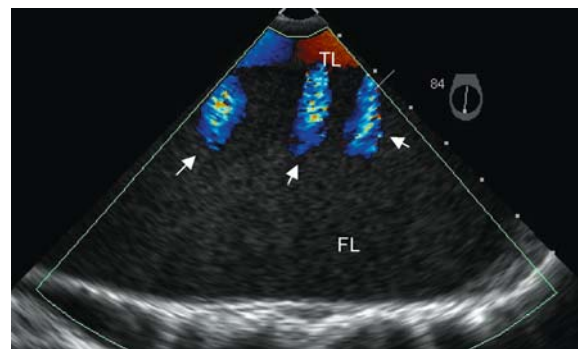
Dissection of the descending aorta. Color Doppler flow of small communications (*arrows*) between the true lumen (TL) and the false lumen (FL) that might correspond to ostia of intercostal arteries
